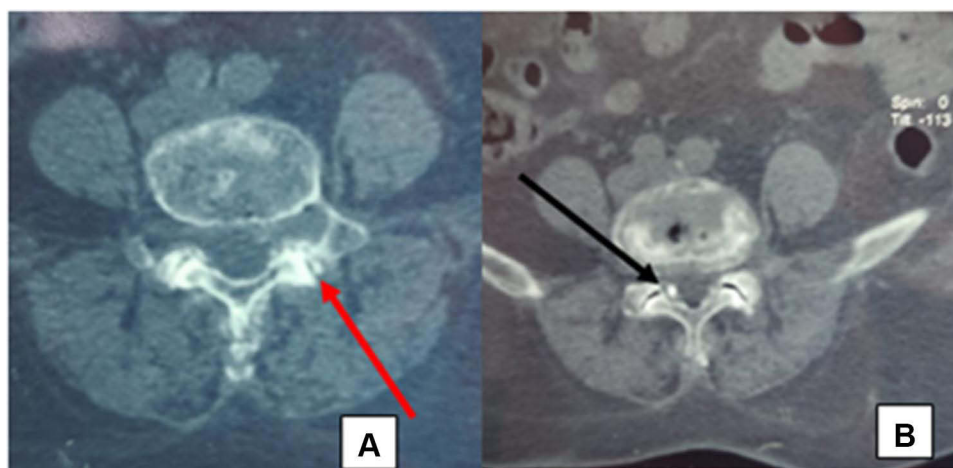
Axial CT-scan image of the lumbar spine, exhibiting calcification of the interapophyseal joint cartilage (Red Arrow) in (A) and ligamentum flavum (Black Arrow) in (B).
